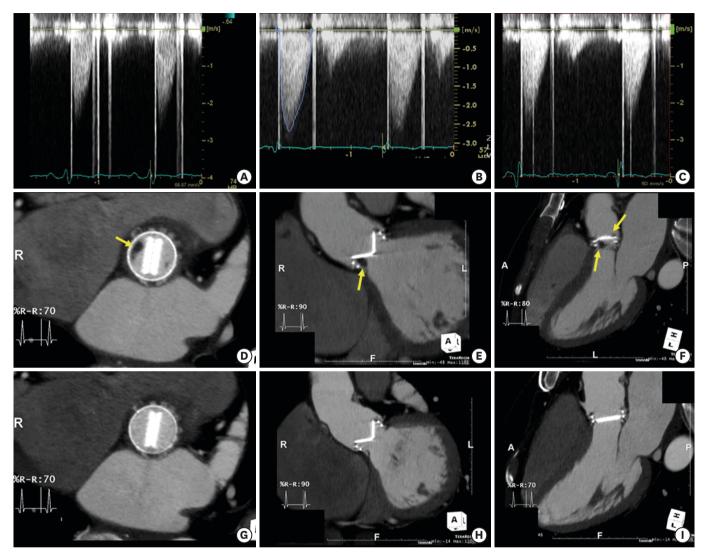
Echocardiography and cardiac computed tomography of subclinical mechanical valve thrombosis. (A) Continuous-wave Doppler of the mechanical aortic valve on postoperative pre-discharge echocardiogram. (B) Continuous-wave Doppler of the mechanical aortic valve on 6-month follow-up echocardiogram. (C) Continuous-wave Doppler of the mechanical aortic valve after intravenous unfractionated heparin therapy for 5 days. (D-F) Low attenuating mass lesions on the right side of the mechanical aortic valve on 6-month follow-up CT. (G-I) Resolution of mass lesions on the right side of the mechanical aortic valve on the follow-up CT after intravenous unfractionated heparin therapy for 5 days.
